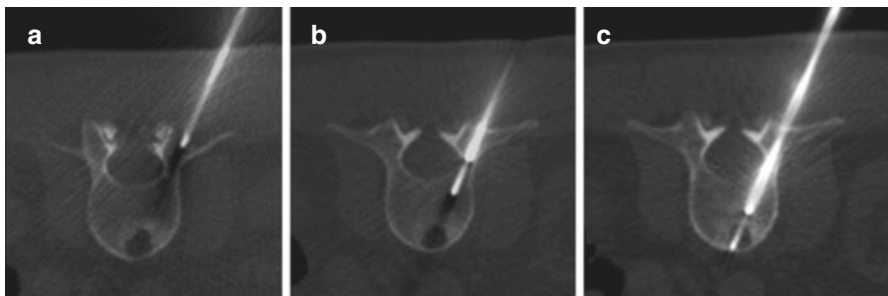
Trans-pedicular lumbar biopsy with CT-guidance: the access cannula is docked through the cortex of the pedicle at the junction between transverse process and articular process (a); a first biopsy is performed with a coaxial device in the trabecular bone of the vertebral body (b); then the cannula is advanced and another coaxial biopsy is performed on a lytic lesion in the anterior third of the vertebral body (c)
